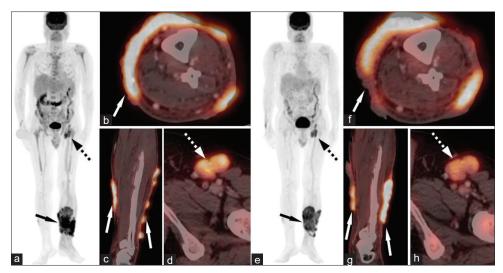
On baseline positron emission tomography–computed tomography (a-d), the maximum intensity projection positron emission tomography image (a) shows focal areas of increased¹⁸F-fluorodeoxyglucose uptake in the lower half of the left leg (arrow) and the left inguinal region (broken arrow). No other abnormal¹⁸F-fluorodeoxyglucose uptake is seen in the rest of the body. Transaxial (b) and coronal (c) positron emission tomography–computed tomography images of the left leg demonstrate¹⁸F-fluorodeoxyglucose avid, ulceroproliferative circumferential cutaneous thickening (arrows) without any definite involvement of underlying muscles and bones. Transaxial positron emission tomography–computed tomography images (d) also show left inguinal¹⁸F-fluorodeoxyglucose-avid lymphadenopathy (broken arrow). The follow-up positron emission tomography–computed tomography done after 8 months (e-h) shows similar findings, but the reduction in¹⁸F-fluorodeoxyglucose avidity of both cutaneous lesion (f-g, arrows) and left inguinal node (h, broken arrow)
